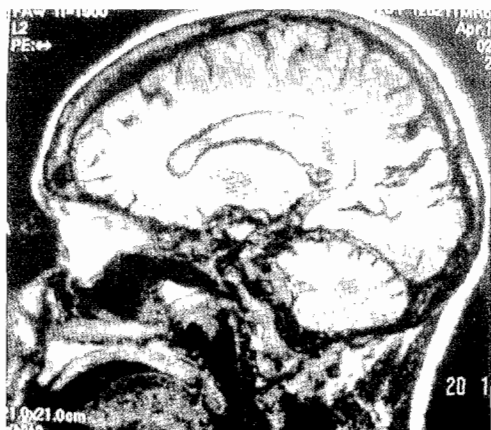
fast FLAIR images for a 33 years man with MS. a cluster of subcallosal striations noted around the corpus callosum.
